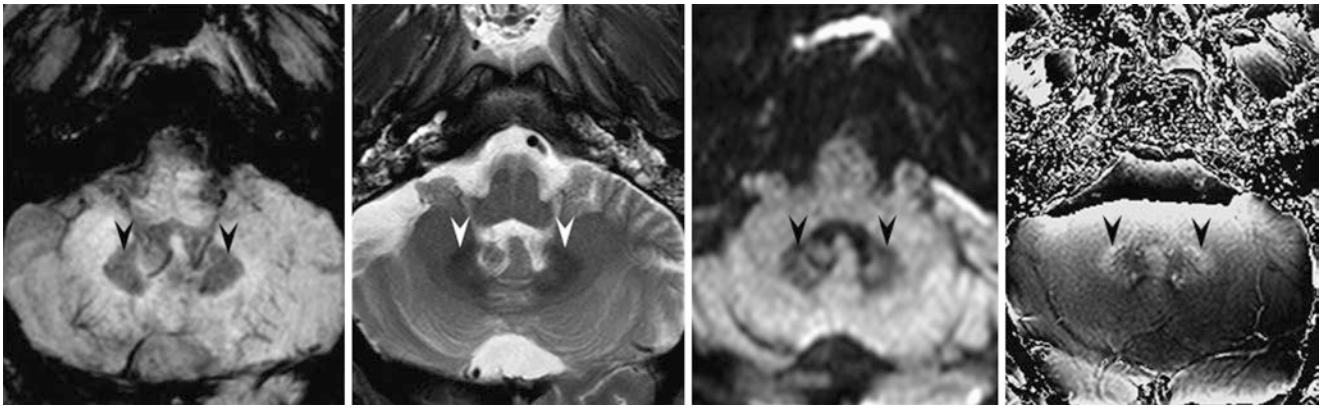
A 54 year old; a 3T MRI demonstrates dark signal of the dentate nuclei on SWI (*left*), T2WI (*left middle*), and DWI (*right middle*). Corresponding bright signal on an unfiltered SWI phase map (*right*) confirms paramagnetic iron
